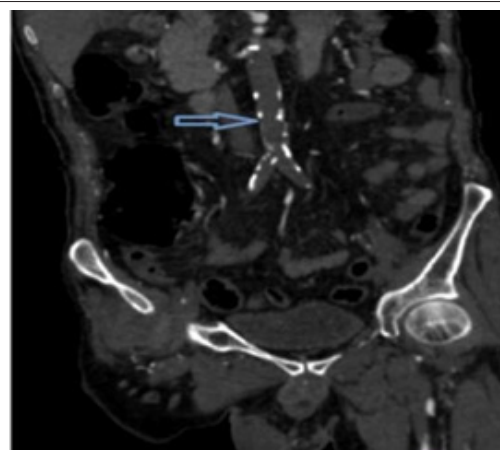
CT scan of abdomen, coronal section showing complete occlusion of infrarenal abdominal aorta and bilateral common and external iliac arteries.
